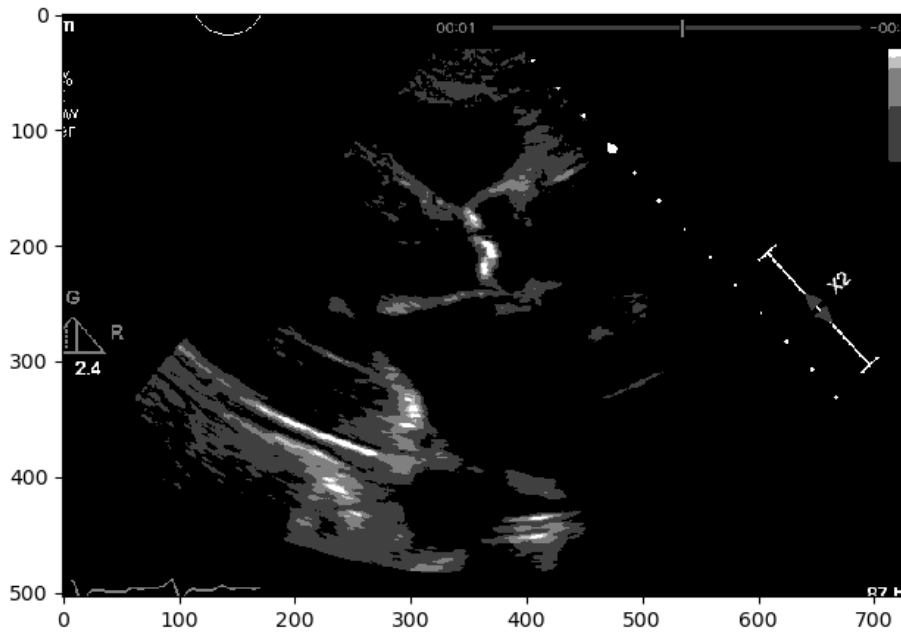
Echocardiography with Region-based Segmentation
